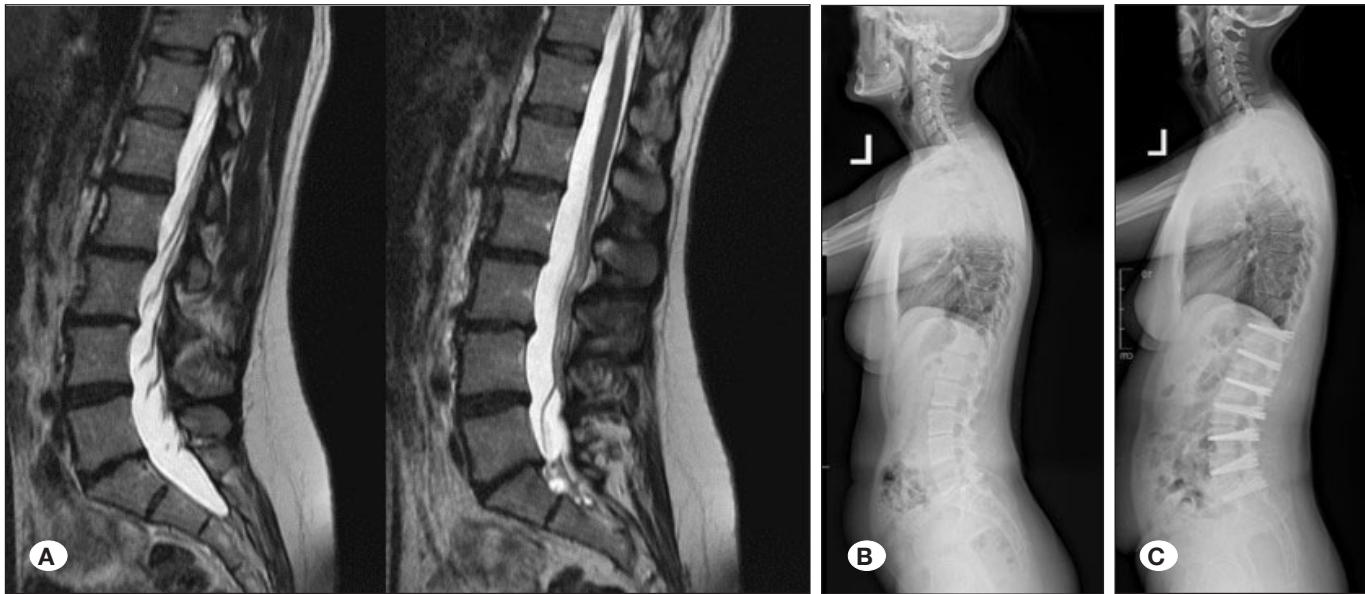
A 46-year-old female patient is unable to stand and walk for a long time due to severe low back pain A) Extensive degenerative disc disease is present on MRI B) her sagittal balance deteriorates forward C) the patient's complaints have improved significantly after the operation and her sagittal balance has improved looks.
